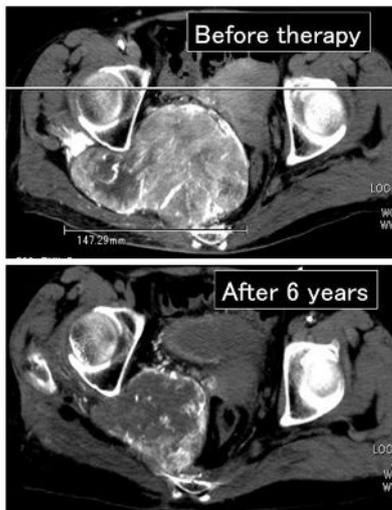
Enhanced CT of patient treated with 70Gy of PBRT
